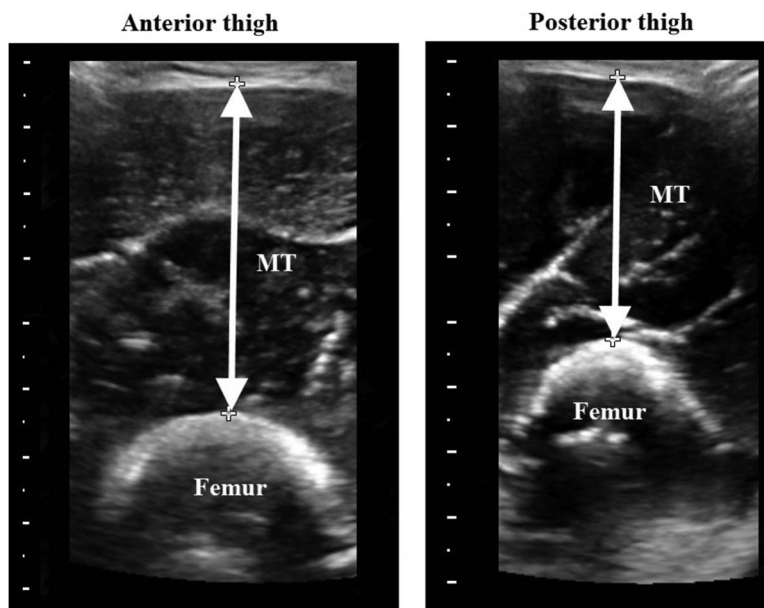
Examples of ultrasound image showing the transverse scans of the anterior thigh (left) and the posterior thigh (right) at 50% of thigh length. MT = muscle thickness.
